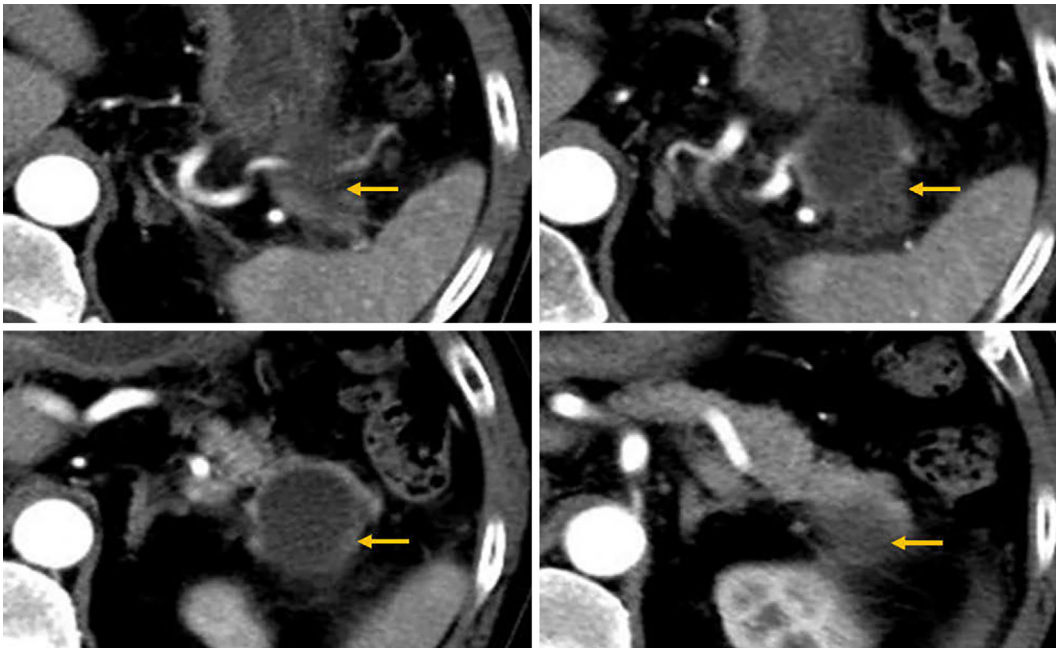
CT image after 1 year and 7 months showing peri-cystic fat stranding (arrow).
